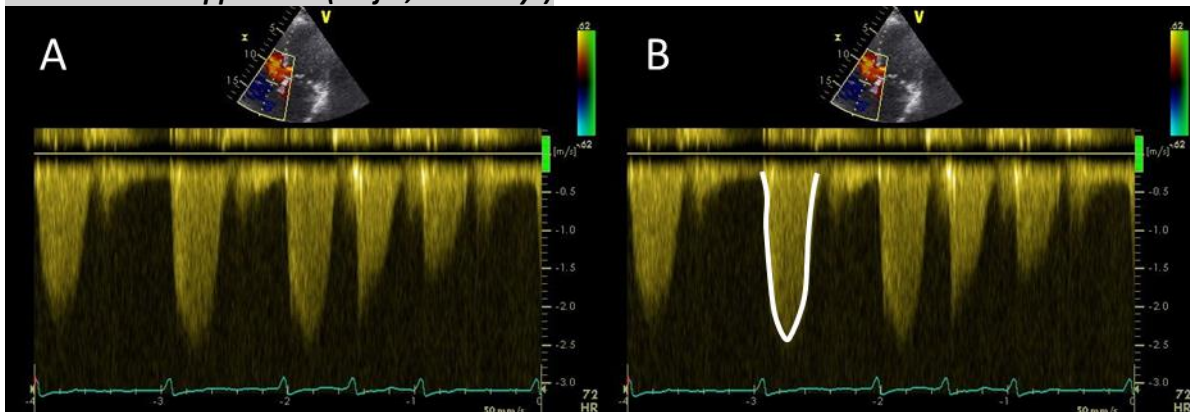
CW Doppler TV (A) and measurement CW Doppler TV (B)
